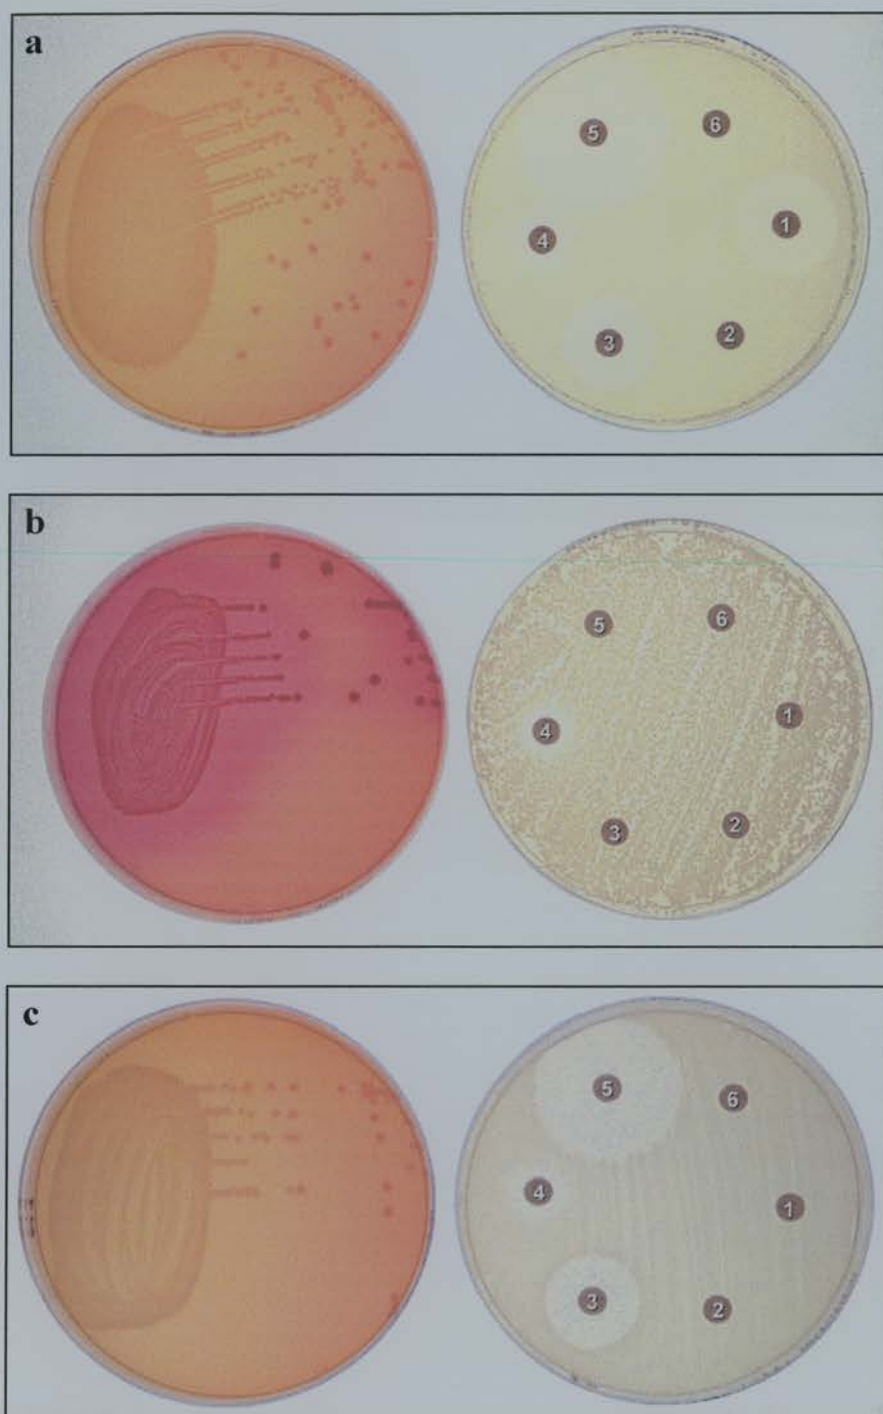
a) The recipient *Escherichia coli* J62-2, b) the donor *Escherichia coli* CT 73 and c) their transconjugants growing on MacConkey agar (left) and showing their individual sensitivity patterns on Mueller-Hinton agar (right). Antibiotic discs: 1-ampicillin, 2-oxacillin, 3-cephalexin, 4-erythromycin, 5-trimethoprim, 6-penicillin.
